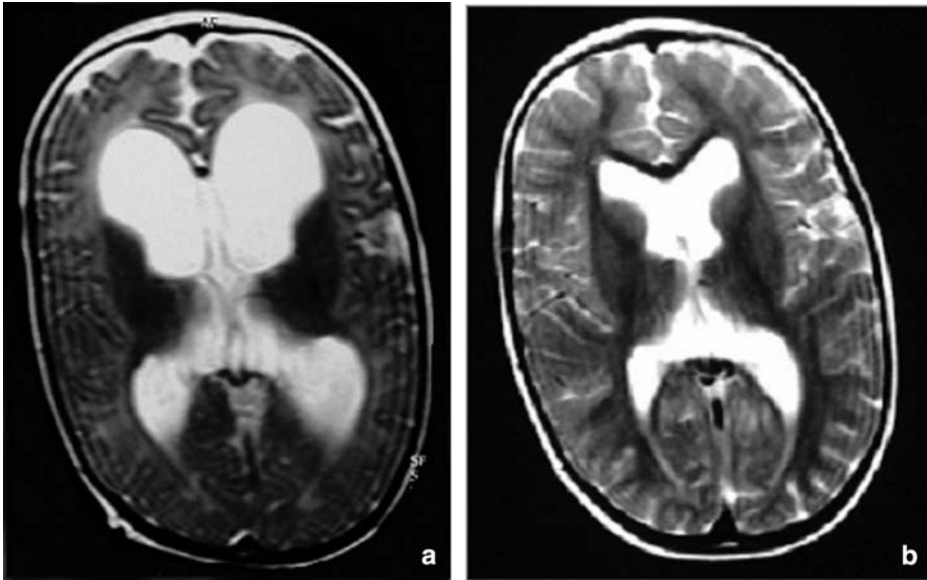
Six month old boy presenting with a 4-month history of progressive macrocrania and vomiting. Pre-operative MRI shows significant ventricular dilatation (a), that regressed only partially after ETV (b)
